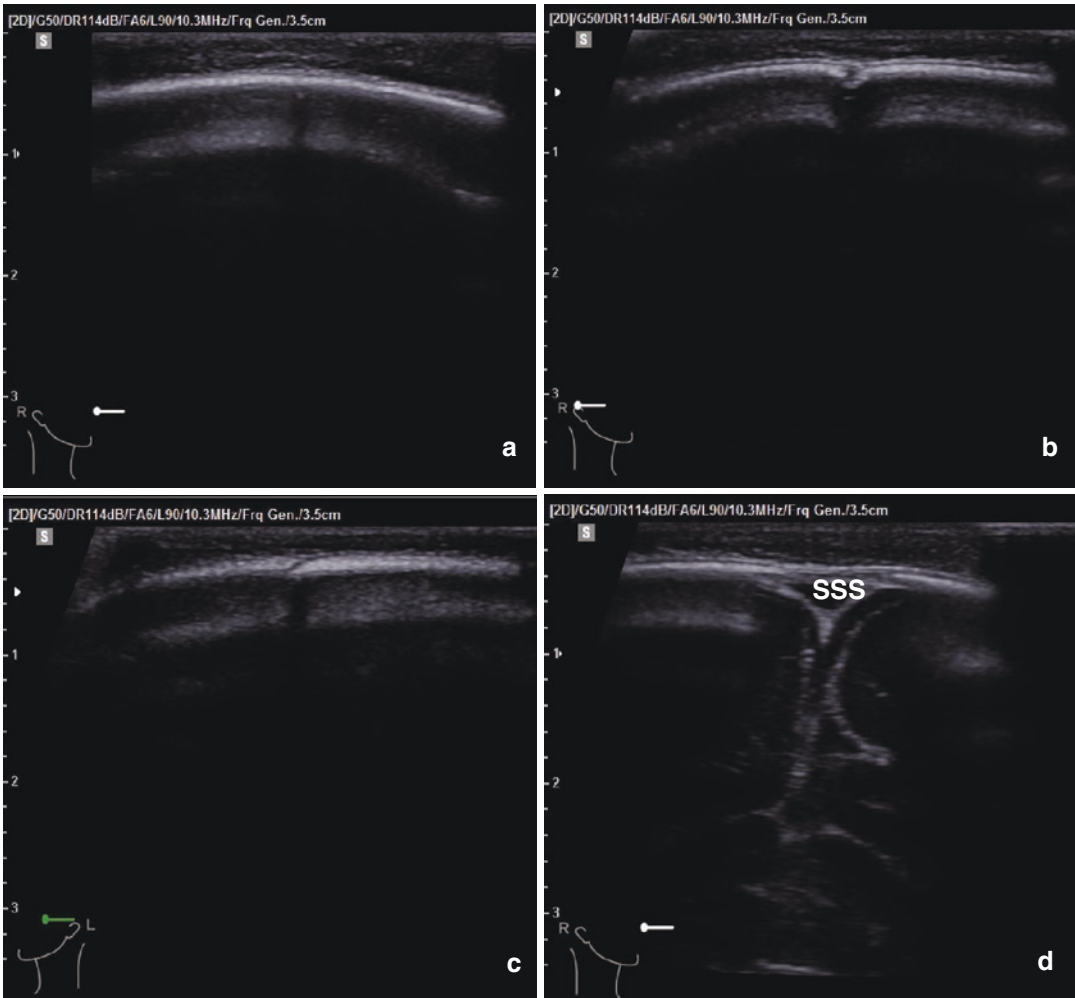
Ultrasonographic image of a closed metopic suture (a) of a 3-month-old girl. The outer layer of the cortical bone of the skull is already closed. A transverse sonogram of the lambdoid suture reveals it as an open hypochoic gap between the hyperechoic frontal bones (b
